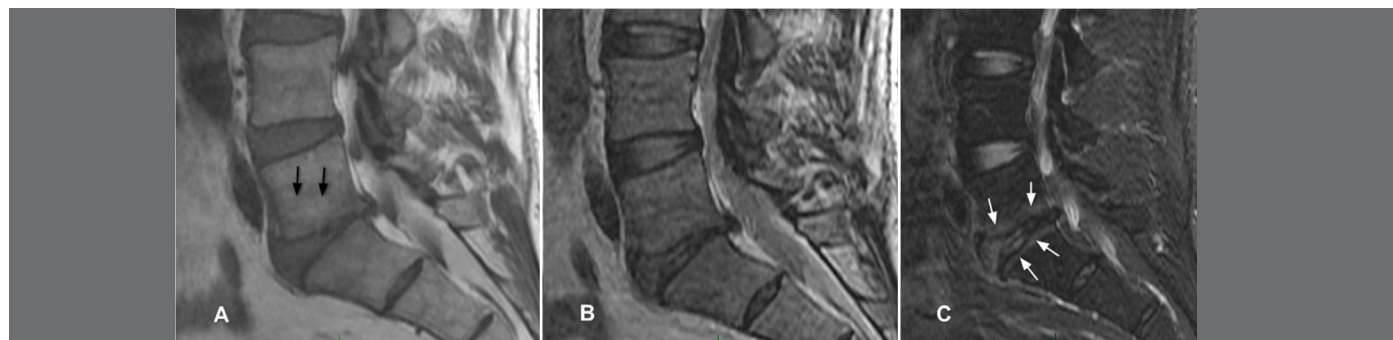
Figures A and B show magnetic resonance images of the lumbosacral spine with the sequences *fast spin echo* (FSE) weighted in T1 and T2. The black arrows in figure A indicate the presence of adipose replacement of the bone marrow adjacent to the lower vertebral plateau of L5, with increased signal intensity suggesting Modic type II. In Figure C, the image from the Dixon FSE T2 sequence with fat suppression clearly shows the concomitant presence of a pattern of bone edema, indicative of Modic I.
